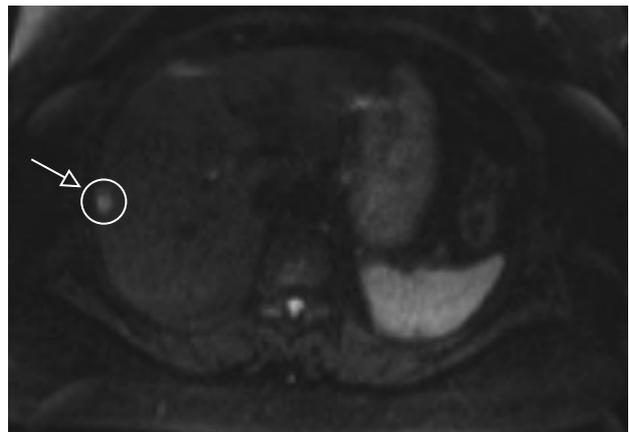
Follow-up magnetic resonance imaging of the hepatic area. The lesion in segment VII of the liver decreased to 1.3×0.9 cm in size.
